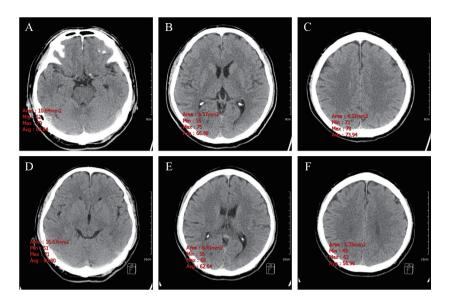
Noncontrast brain CT before and after rt-PA infusion. (A–C) Initial noncontrast brain CT revealed no intracranial hemorrhage and no early infarction sign. However, high attenuation was observed in the superior sagittal sinus and the right transverse sinus. (D–F) The attenuations in the venous sinuses decreased after rt-PA infusion, which may suggest partial recannalization of the superior sinus and the right transverse sinus. The average attenuations before rt-PA were 68.6HU in transverse sinus (A), 66.5HU and 73.9HU in superior sagittal sinus (B, C), and became 60.8HU in transverse sinus (D), 62.6HU and 56.9HU in superior sagittal sinus (E, F) after rt-PA. (CT, computed tomography; rt-PA, recombinant tissue plasminogen activator; HU, hounsfield unit; min, minimum; max, maximum; avg, average)
